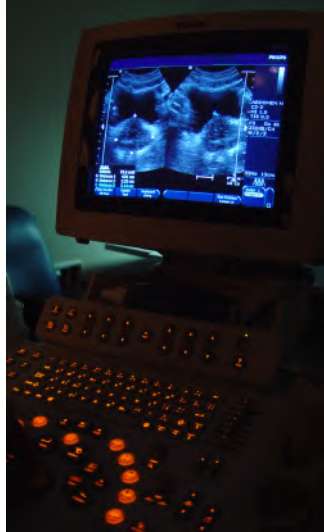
Ultrasound of the urinary bladder and hyperplastic prostate. [Image obtained from [3], used under a Creative Commons Attribution 3.0 Unported license]
